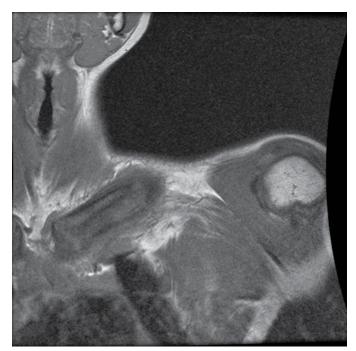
A coronal T1-weighted magnetic resonance imaging (MRI) scan showing an increased thickness of left clavicle and changes in the surrounding soft and muscular tissue and bulky with numerous locoregional ganglion formations.
